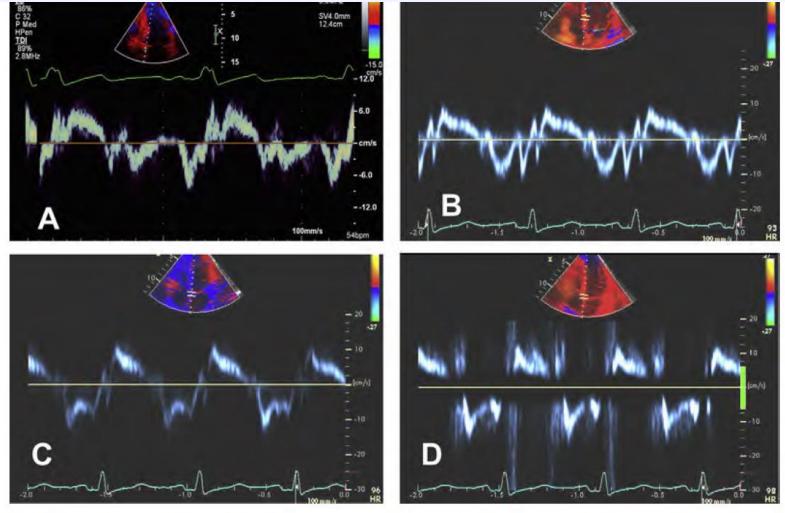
Tissue Doppler recordings of septal mitral annular velocities. In (A), Doppler settings and sample volume location are optimal, whereas in (B) the sample volume is placed in the ventricular septum (not annulus). Doppler setting are suboptimal in (C) with low gain and in (D) with high filter.
